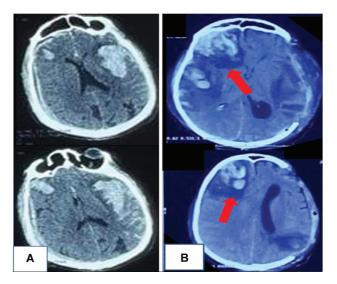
(A) Preoperative computed tomography (CT) scan images suggestive of large left frontal contusion with midline shift. (B) Postoperative CT scan images are suggestive of evacuation of the left frontal contusion along with the appearance of fresh frontal and temporal contusions on the right side (*red arrow*).
